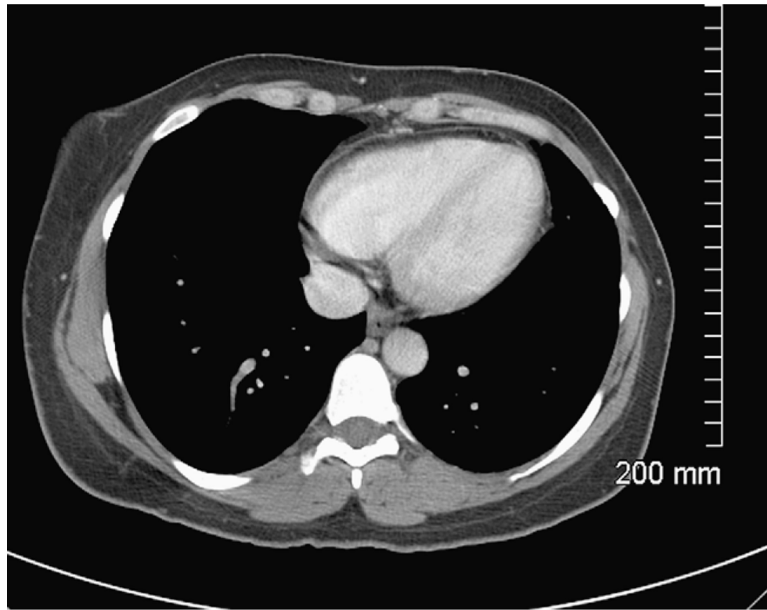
Computed tomography of the chest with intravenous contrast showing resolution of septal infarction after treatment.
